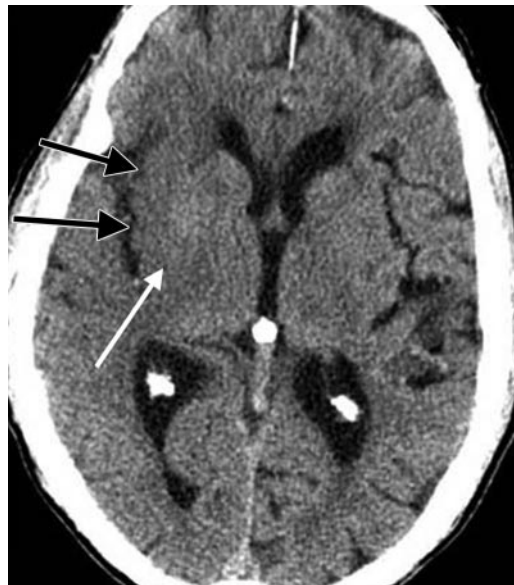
Axial unenhanced CT image, obtained in a 73-year-old woman 2½ hours after the onset of left hemiparesis, shows hypoattenuation and obscuration of the posterior part of the right lentiform nucleus (white arrow) and a loss of gray matter–white matter definition in the lateral margins of the right insula (black arrows). The latter feature is known as the insular ribbon sign.
